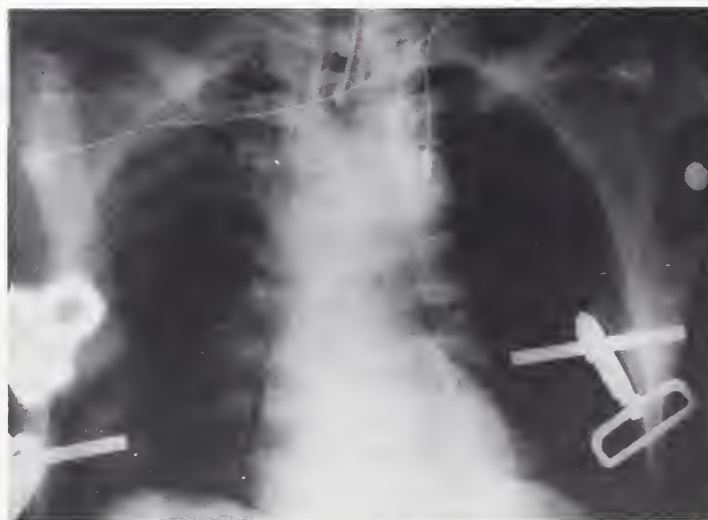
Chest x-ray immediately following intubation.
